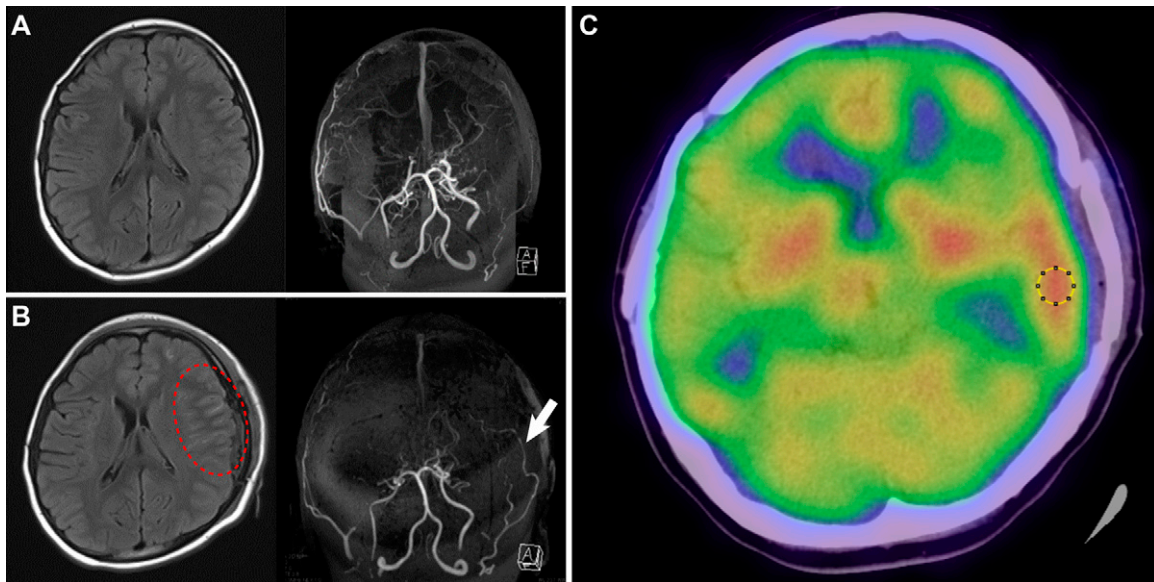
Symptomatic hyperperfusion after left combined revascularization in a 12-year-old patient with MMD. A: No stroke lesions were found on MRI (*left*). On MRA, the bilateral internal carotid artery was highly stenotic at the terminal portion, and the ACA and MCA had disappeared (*right*). MMVs were bilaterally developed, and the PCA was not affected. B: On fluid-attenuated inversion recovery MRI, no new stroke events had occurred, but a sulcal hyperintensity signal had appeared, mainly around the anastomotic site in the frontal lobe (*left, red dotted ellipse*). An MRA showed an apparent visualization of the STA graft (*right, white arrow*). C: On SPECT performed on POD 3, findings of focal hyperemia were observed on the left frontotemporal lobe, and the patient was diagnosed with symptomatic hyperperfusion (*yellow circle*).
